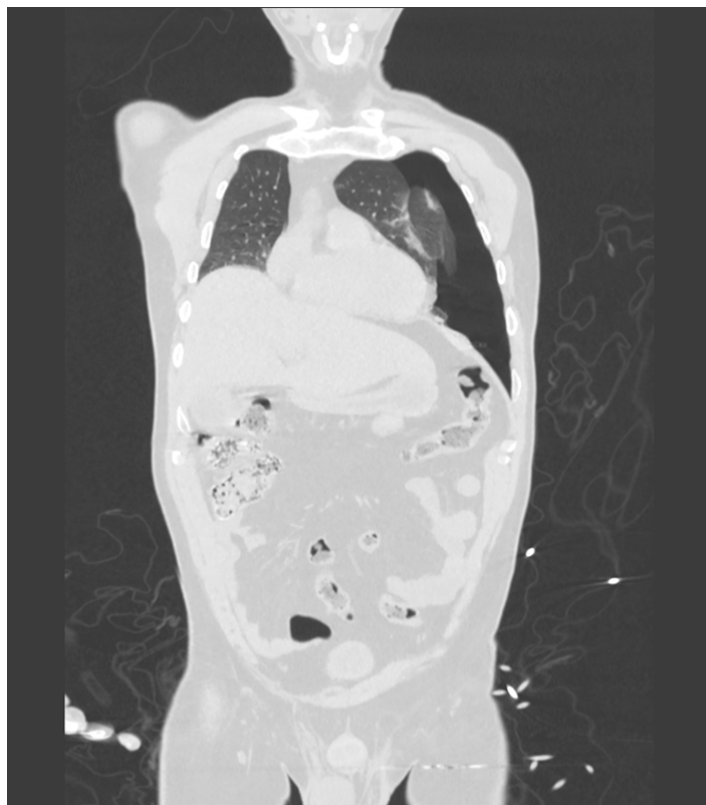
Coronal computed tomography image showing traumatic rupture of the left hemidiaphragm with herniation of abdominal viscera into the left hemithorax and associated hemopneumothorax.
